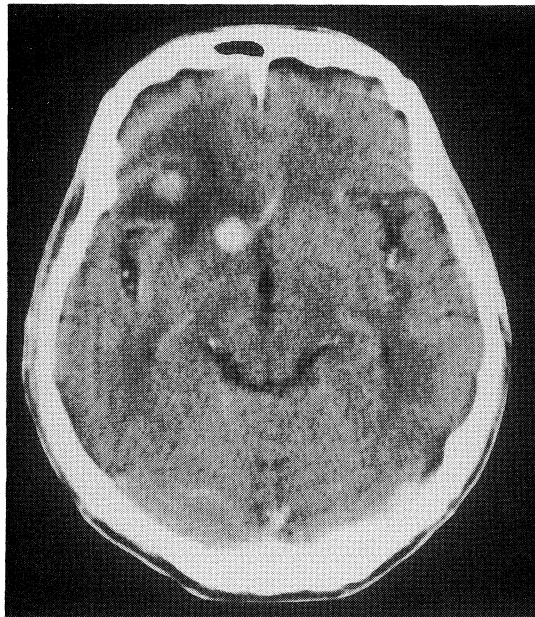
CT of the brain showing enhanced masses in the right frontal lobe and caudate nucleus.
